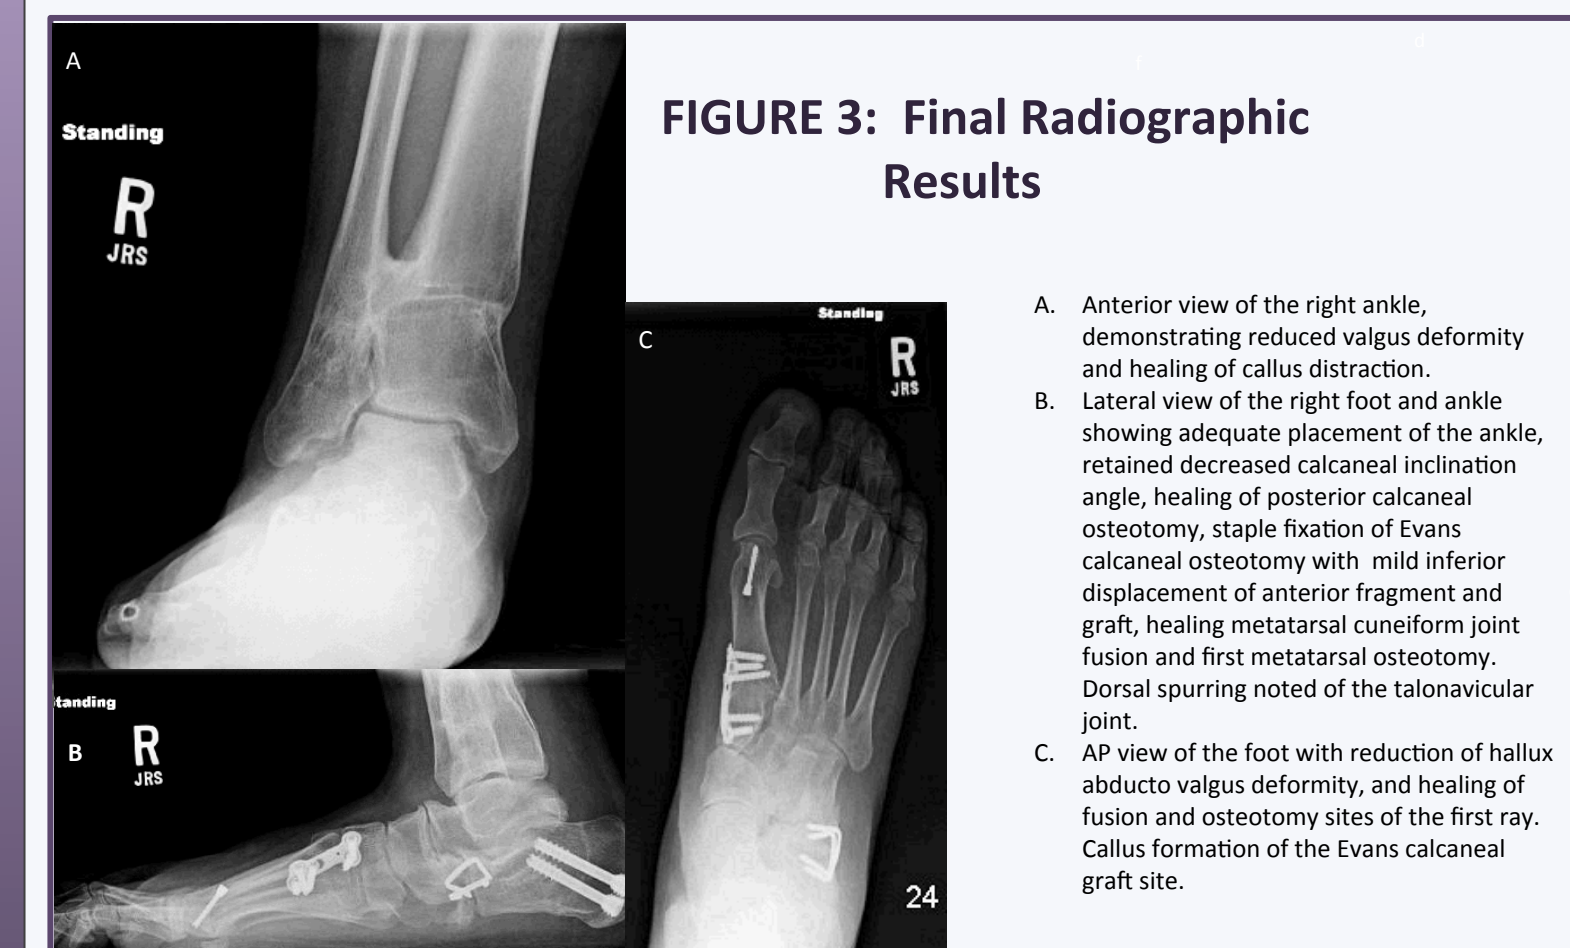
Final Radiographic Results
